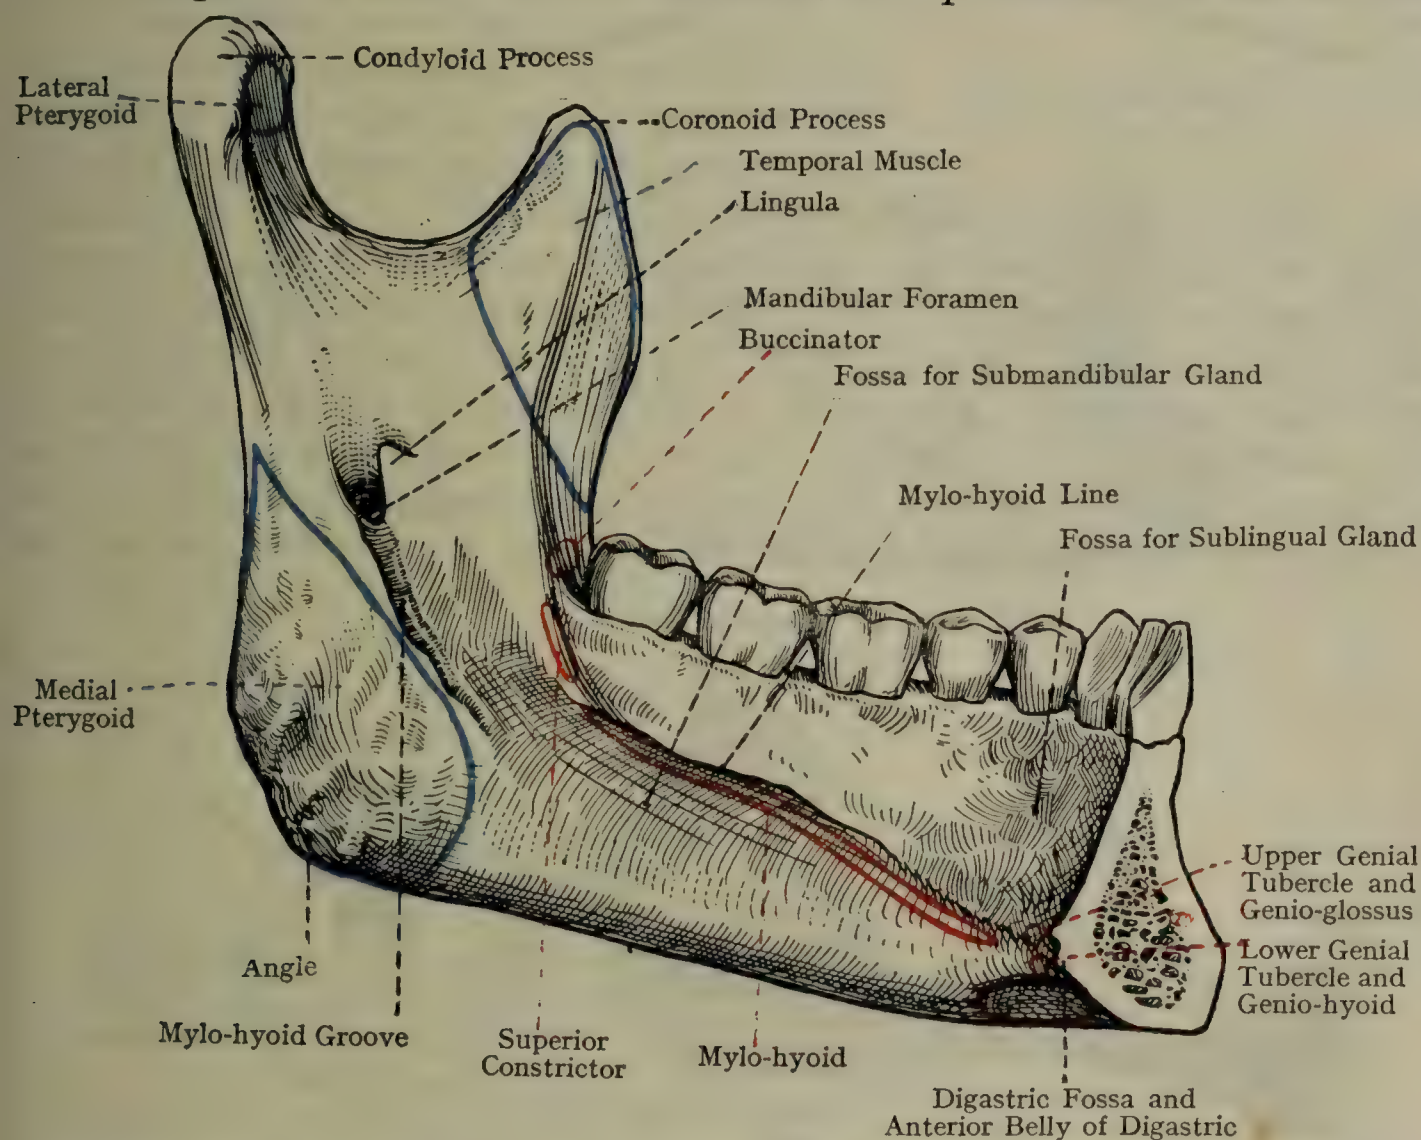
THE LEFT HALF OF THE MANDIBLE (MEDIAL ASPECT).
